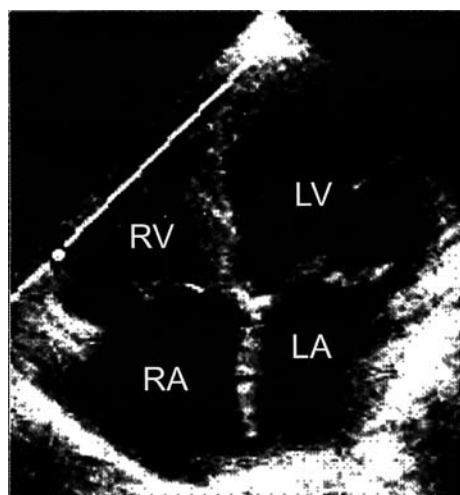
Sample volume placed at the edge of the lateral tricuspid annulus, determined from the apical 4 chamber view for measurement of the tricuspid annular velocity by doppler tissue imaging. RV - right ventricle, LV - left ventricle, RA - right atrium, LA - left atrium
